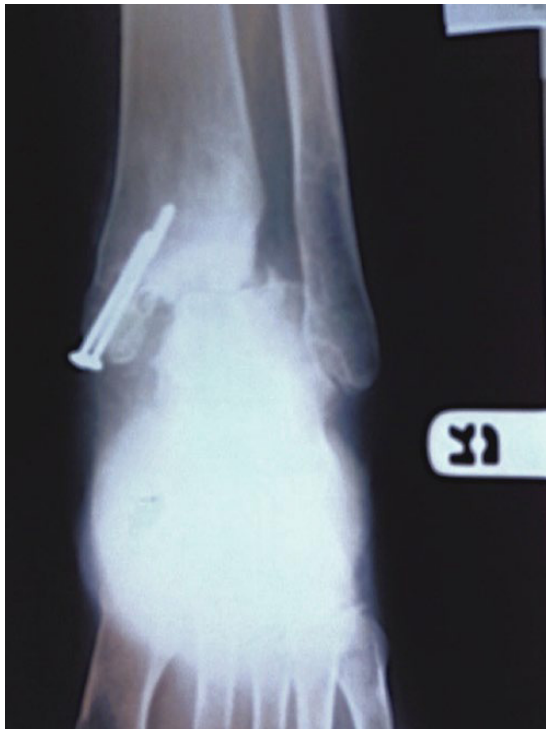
Anteroposterior radiograph of a patient who presented with persistent pain following fixation of a medial malleolar fracture revealing a missed syndesmotom injury.
